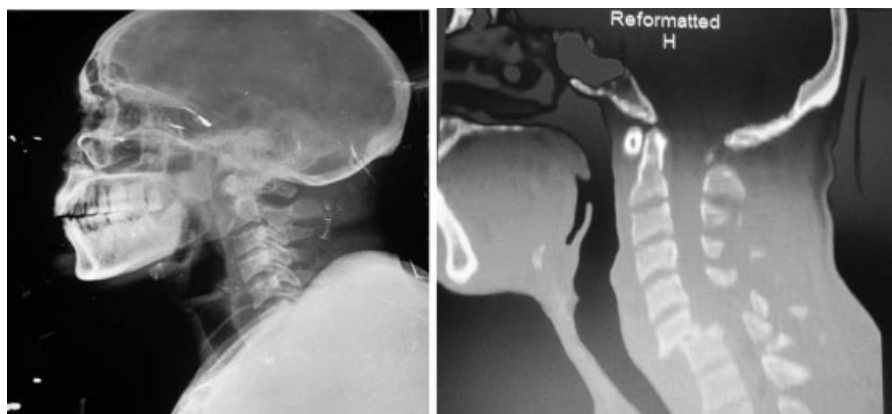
Fracture dislocation C5/C6 and a break in the posterior cortical margin of C2 body demonstrable in CT spine (JPG, 960–720 pixels). CT, computed tomography.
